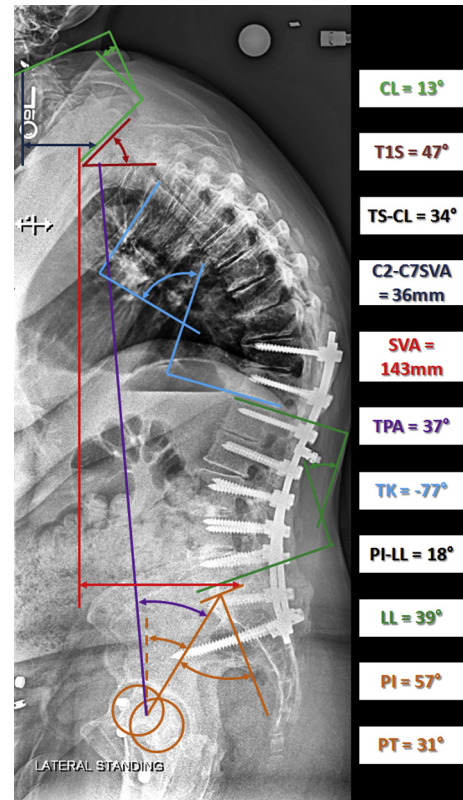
Clinical preoperative and postoperative changes in radiographic parameters for thoracolumbar and cervical deformities. CL, cervical lordosis; TPA, T1 Pelvic Angle; PI-LL, pelvic incidence and lumbar lordosis; preop, preoperative; PT, pelvic tilt; SVA, sagittal vertical axis; TK, thoracic kyphosis; T1S, T1 slope.
